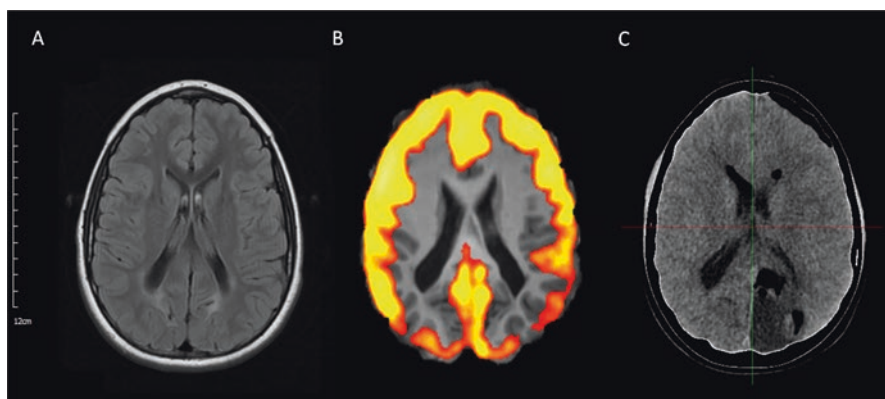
Case 3. (a) Preoperative axial FLAIR MRI showing bilateral occipital lobe injury; (b) preoperative PET depicting hypometabolism in the occipital lobes, more pronounced on the left side (areas in yellow indicate normal cortical metabolism); and (c) postoperative CT showing the resection in the left occipital lobe
